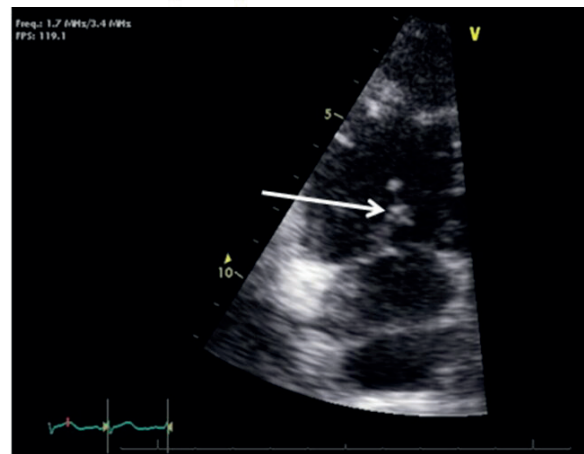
Echocardiogram showing vegetation on the atrial aspect of the tricuspid valve (arrow).
